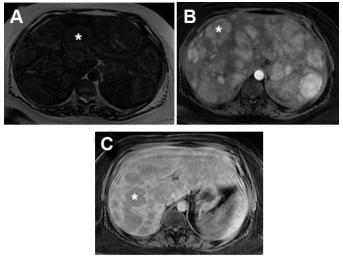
Magnetic resonance imaging of the liver. (A) T2 sequence demonstrates numerous hepatic lesions (*) that are mildyT2 hyperintense. (B) These lesions (*) enhance avidly in the arterial phase with intravenous gadolinium. (C) Liver lesions (*) are relatively hypointense in the venous phase sequence.
